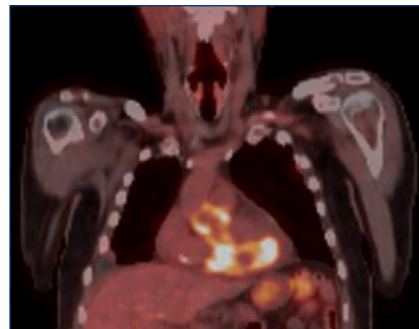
PET/CT showing new PET avid (SUV max 17.4) left ventricular intra-cardiac mass measuring 8 cm in right-to-left dimension.
